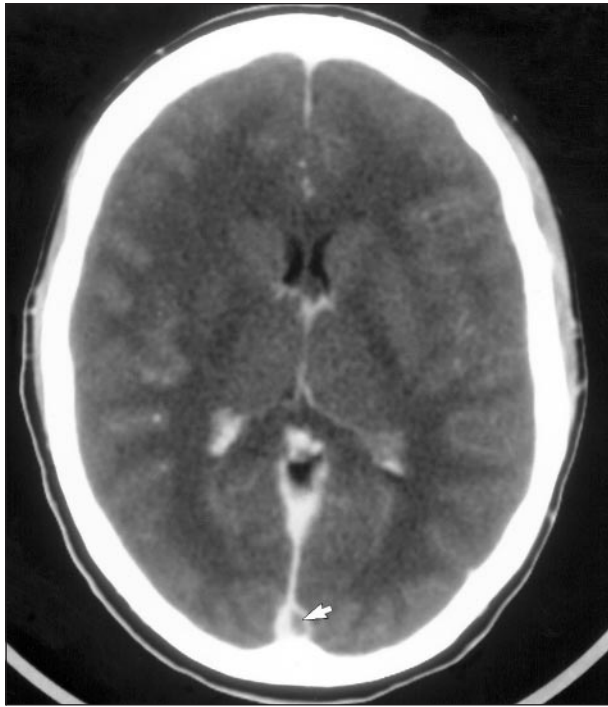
Enhanced computed tomographic scan with filling defect in the superior sagittal sinus with partial delta sign (arrow).
